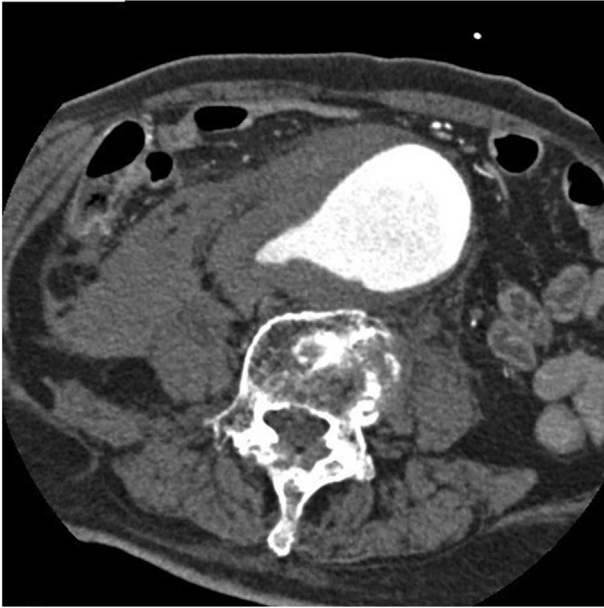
Pre-operative contrast enhanced CT showing the RAAA in the axial view.
